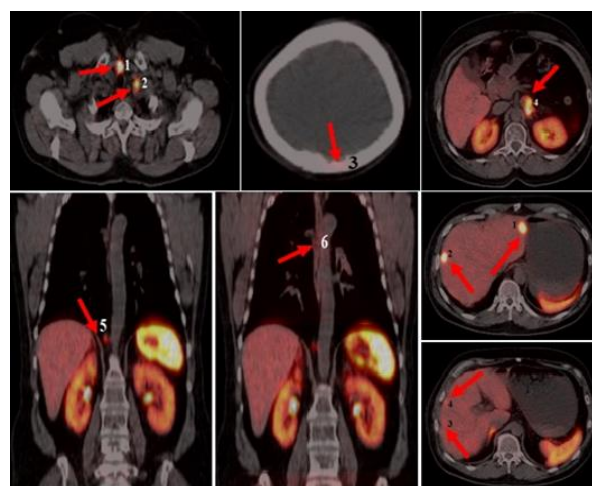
PET/CT images of p3 and p4. The patients were scanned 60 minutes after injection of about 5mCi of ^{68}Ga -DOTATATE. The five first images show the locations of six tumors of the p4 (tumor 3 and tumor 6 of this patient is not clear in these figures). The two last images show the locations of four tumors of the p3.
